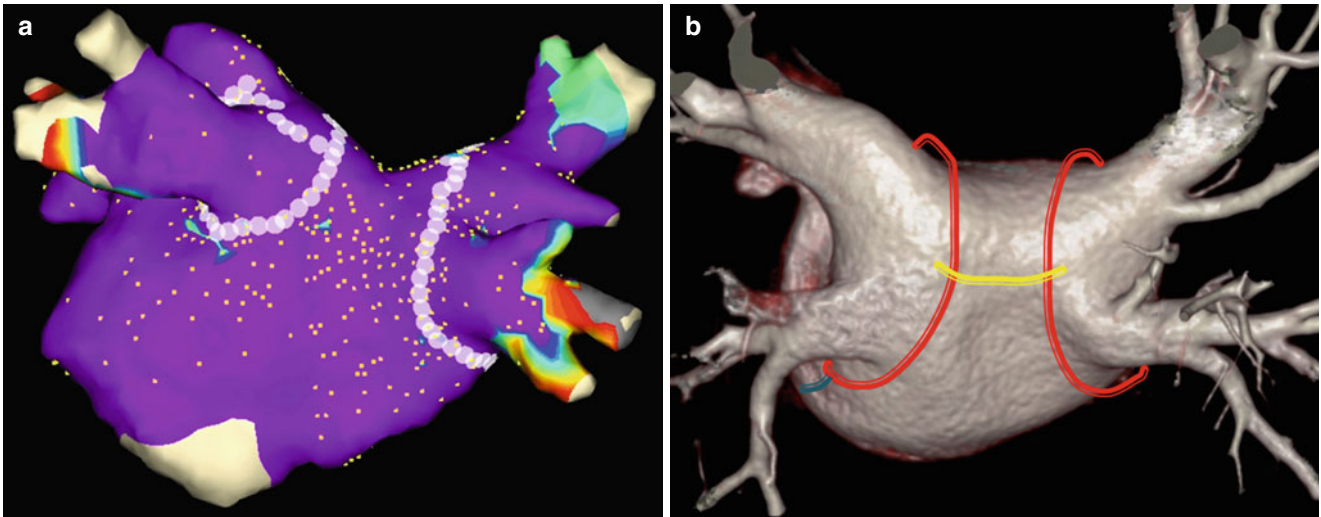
Catheter ablation strategies for atrial fibrillation. Posterior electroanatomic map (a) and volume-rendered CT image (b) of the left atrium and pulmonary vein show the circumferential pulmonary vein ablation. In volume-rendered CT image (b), circumferential ablation
